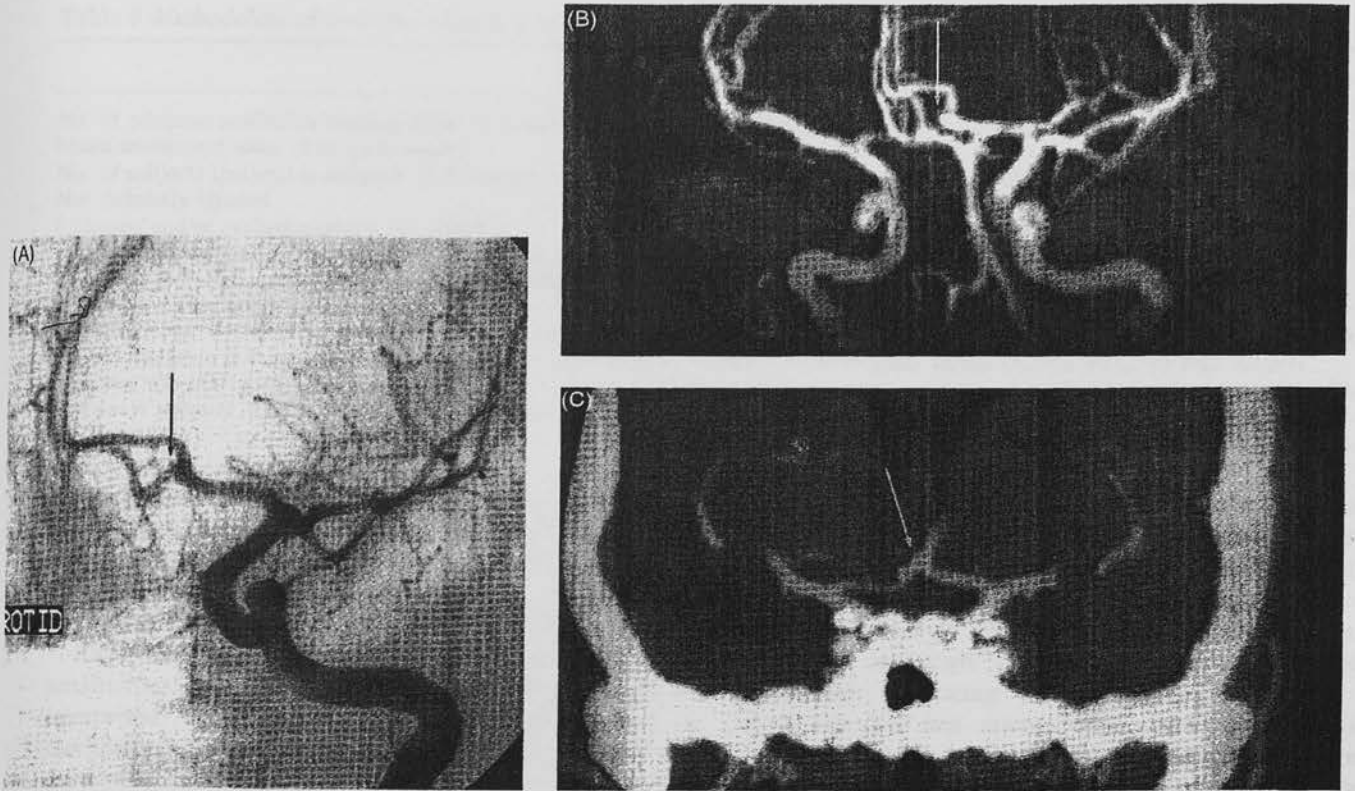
Imaging of a left anterior communicating artery aneurysm (arrow) with the gold standard intra-arterial digital subtraction angiography (A), and two non-invasive techniques, i.e. magnetic resonance angiography (B) and computed tomographic angiography (C). The aneurysm is small and very difficult to identify with certainty using the MRA or CTA.
